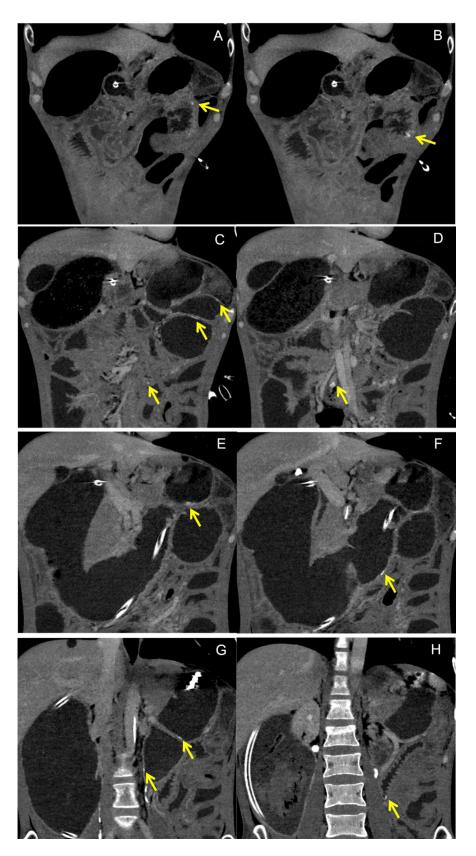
Trans-arterial contrast-enhanced computed tomography (CT) of the superior mesenteric artery (SMA). Trans-arterial contrast-enhanced CT with a catheter placed into the SMA was performed, and it showed multiple microbleeds in the small intestine (yellow arrow).
